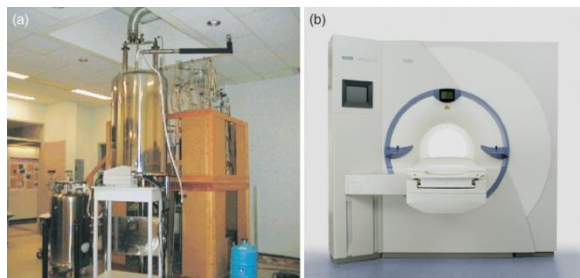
(a) Vertical experimental 11.7-T MRI system (IBD/NRC), magnet (Magnet Scientific, England), and console (Bruker, Germany). (b) 3-T Siemens Trio MRI system.
